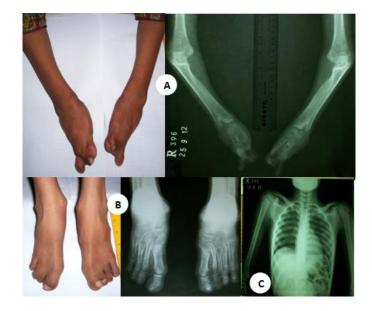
Photographs and radiographs of proband IV-3
